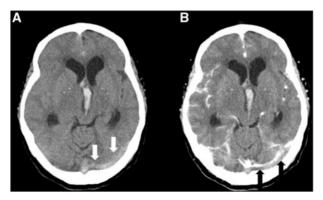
(A) Cord sign—a hyperdensity (white arrows) within transverse sinus on non-contrast CT, (B) transverse sinus blockage (black arrow) on contrast CT.
